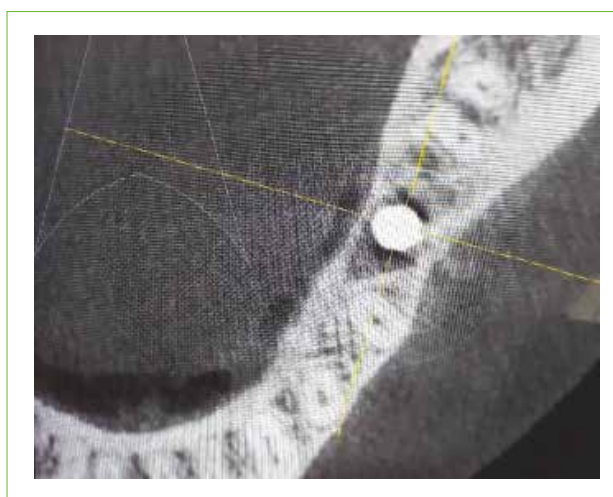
Peri-implant radiolucency at 3rd month (sagittal plane, CBCT).
